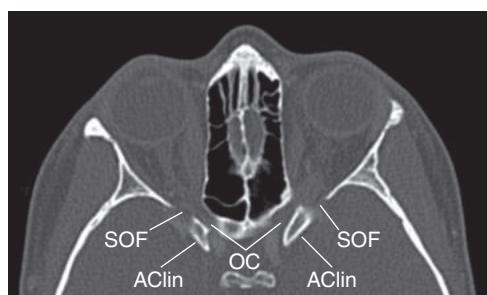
Axial computed tomography scan of the orbits. The superior orbital fissure (SOF) passes above and below the plane of the optic canal (OC) and is commonly mistaken for the OC. The OC lies in the same plane as the anterior clinoid processes (AClin) and may be cut obliquely in scans so that the entire canal length does not always appear. (Courtesy of William R. Katowitz, MD.)
